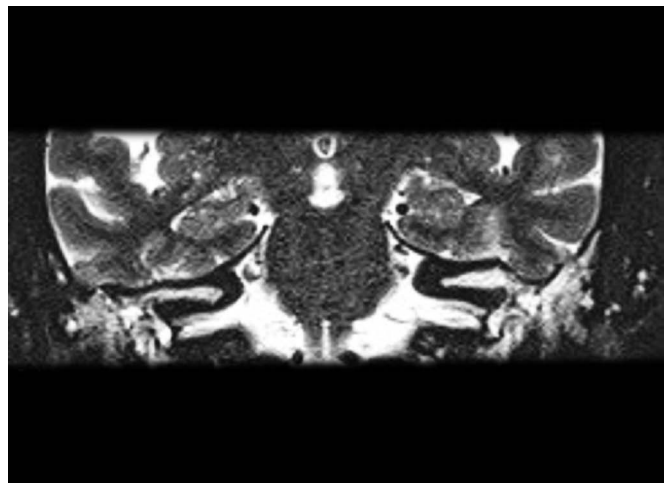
Coronal, T2-weighted magnetic resonance imaging (MRI) depicting bilateral mastoid cavity cerebrospinal fluid (CSF) leaks via tegmen dehiscences. An encephalocele may be seen protruding through the left lateral aspect of the tegmen plate.
